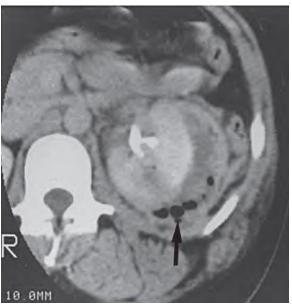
Left perinephric abscess. This contrast-enhanced computed tomography scan demonstrates a large left perinephric abscess containing gas (*arrow*).
